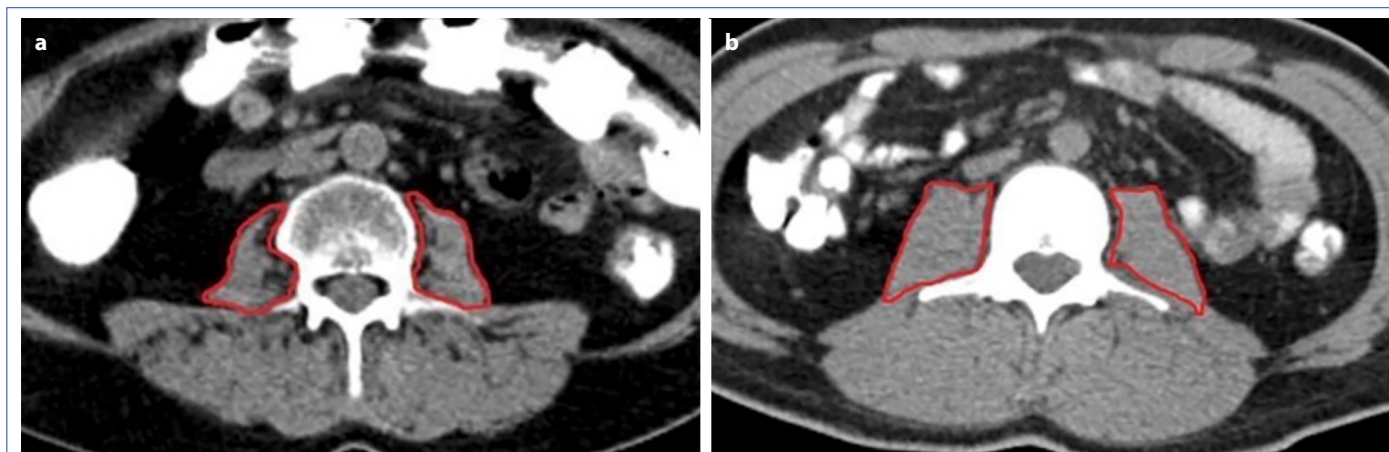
(a) On the left, a CT section taken from the L3 vertebra level of a 56-year-old female patient (Total psoas area: 736 mm²), and (b) a CT section taken from the L3 vertebra level of a 24-year-old male patient (Total psoas area: 2403 mm²).
